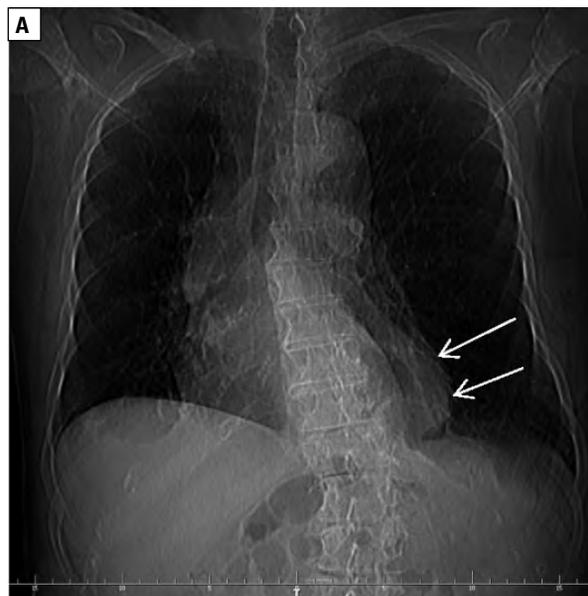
A — posterior–anterior chest X-ray; B — lateral chest X-ray. A significant scoliosis and a brighter area partially projecting onto the heart silhouette (black arrows)
